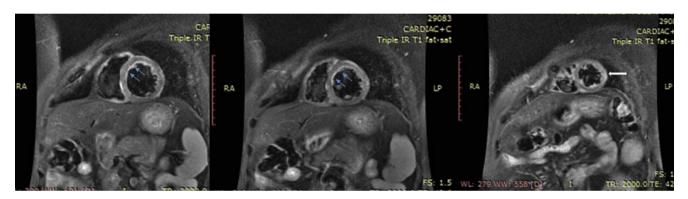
Contrast enhanced cardiac MRI (CMRI) showed abnormal sub-endocardial (arrows) and mural (Block arrow) late gadolinium enhancement (LGE) in Left Ventricle.
